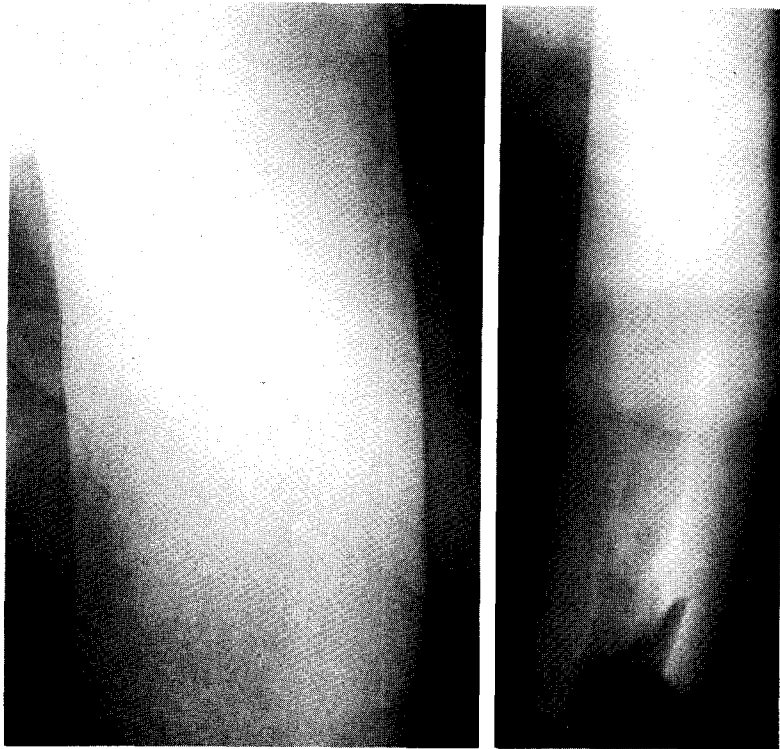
■ Left, radiograph of normal left tusk showing homogeneity of tusk. Right, radiograph of infected right tusk showing jagged edges and central hollow canal that extends past skinfold deep into central canal.
